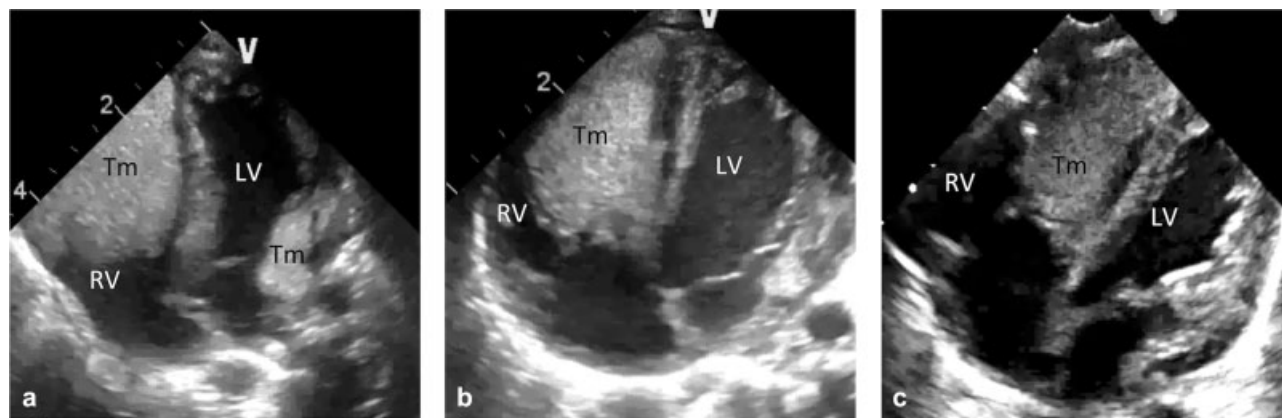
Figures show view of four chambers on echocardiography. (a) The patient at birth. Multiple tumors were found in both ventricles. The largest rhabdomyoma occupied most of the right ventricular cavity (size: 35 × 21 mm). (b) The patient at day 20. The largest rhabdomyoma showed regression (size: 28 × 15 mm). (c) The patient at day 42. The largest rhabdomyoma significantly regressed (size 24 × 11 mm). LV, left ventricle; RV, right ventricle; Tm, tumor.
